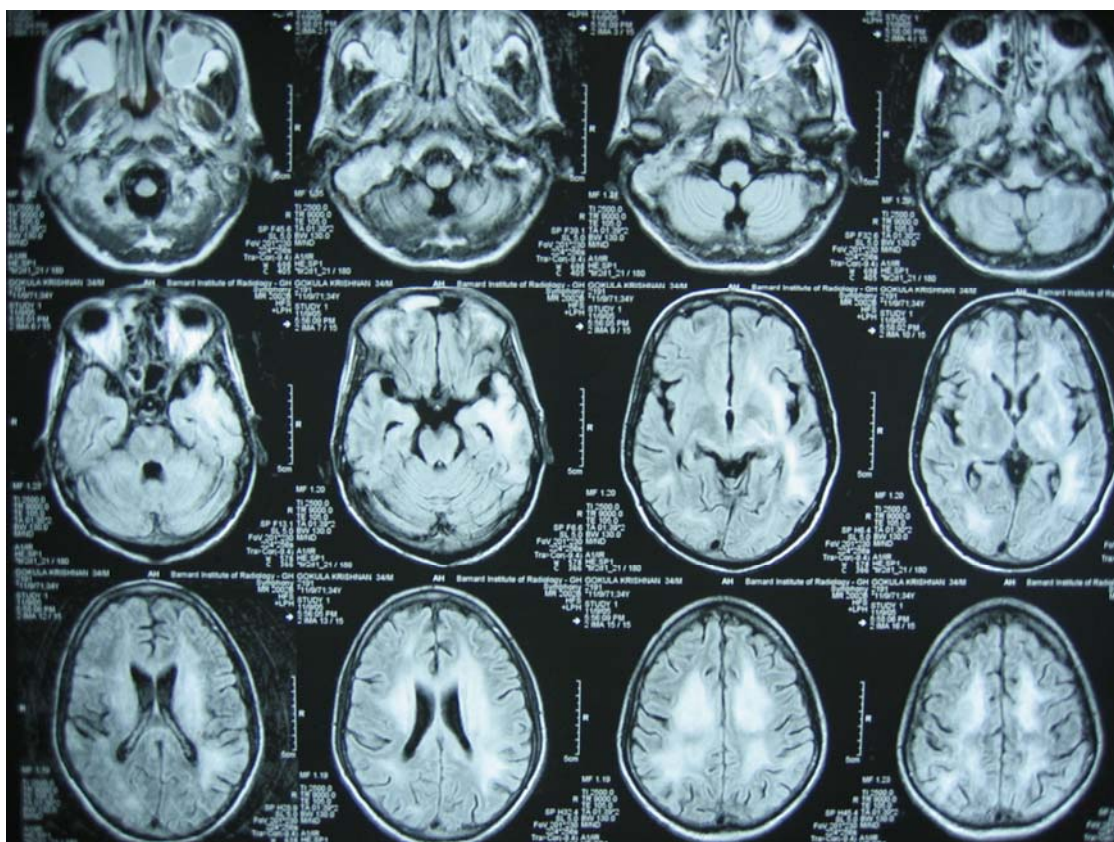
MRI Brain (Saggital section) showing extensive white matter lesions (PML)
